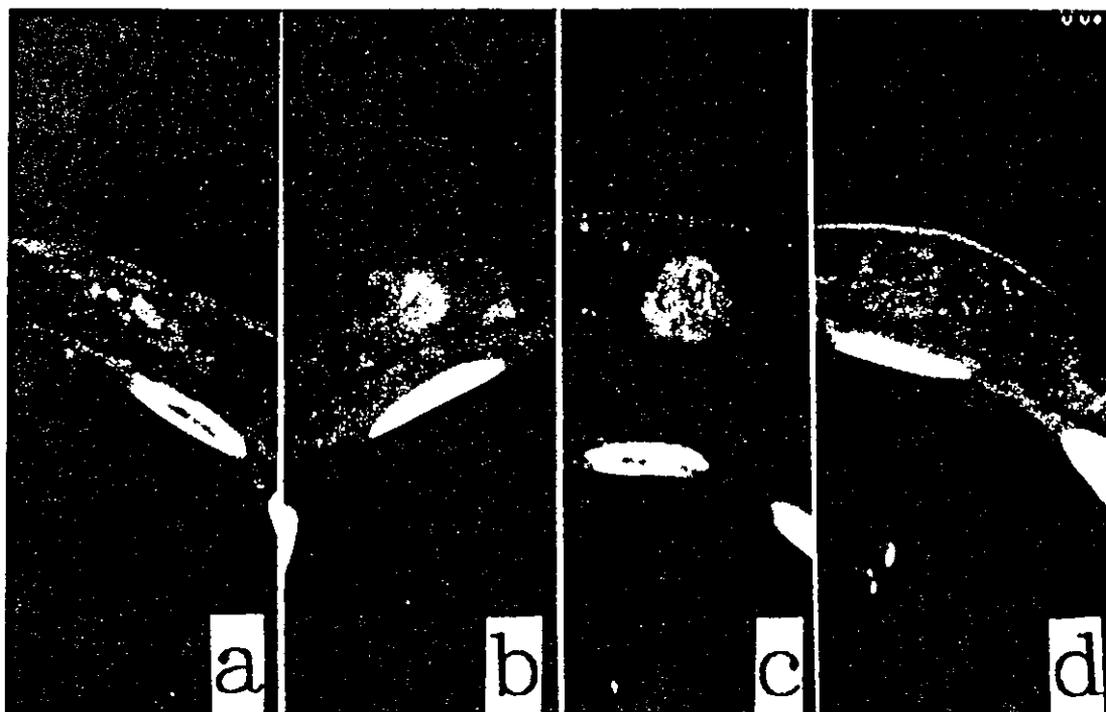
Examples of patterns of enhancement on contrast-enhanced computed tomography (CE-CT): (a) multiple spots type, (b) tumor and spots type, (c) solid tumor type, and (d) no enhancement.
